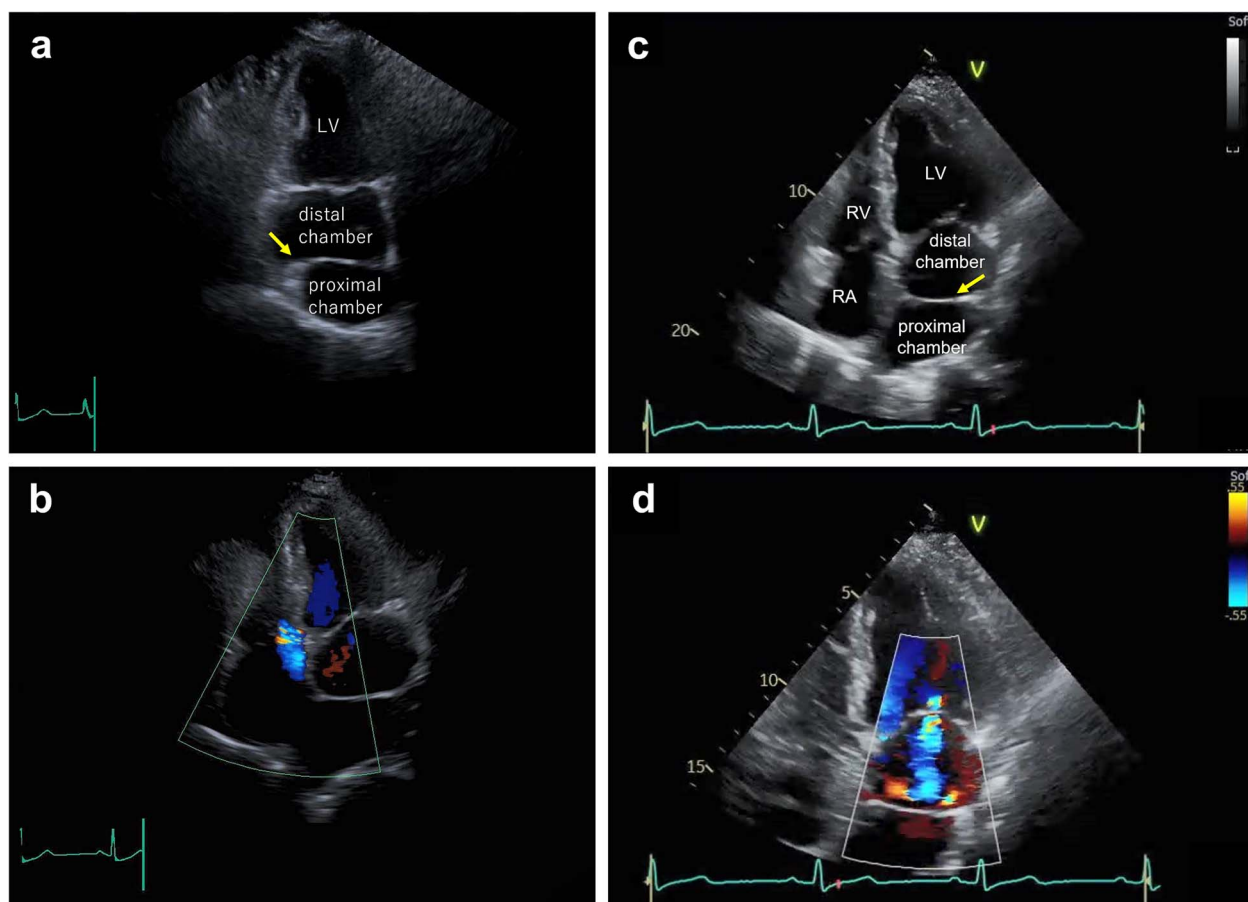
Transthoracic echocardiography on admission. Echocardiography shows dilation of the left atrium, which is divided by an abnormal septum (arrow, a and c) and moderate tricuspid and severe mitral valve regurgitation (b and d). LV, left ventricle; RA, right atrium; RV, right ventricle.
